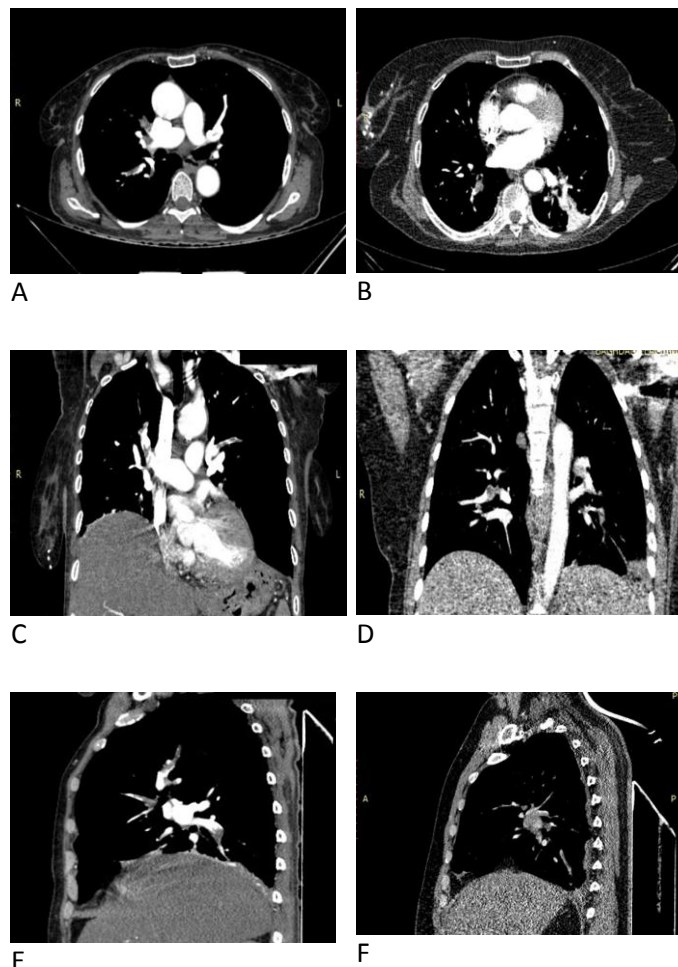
Pulmonary CTA performed using the conventional protocol (a,b,c) and the evaluated low-voltage, low contrast medium protocol (d,e,f). Axial images (a,d), reformatted coronal images (b, e), and reformatted sagittal images (c, f). The study performed with the conventional pulmonary CTA technique. A similar example is shown in the study obtained with the 80 kV protocol demonstrated segmental PE.
